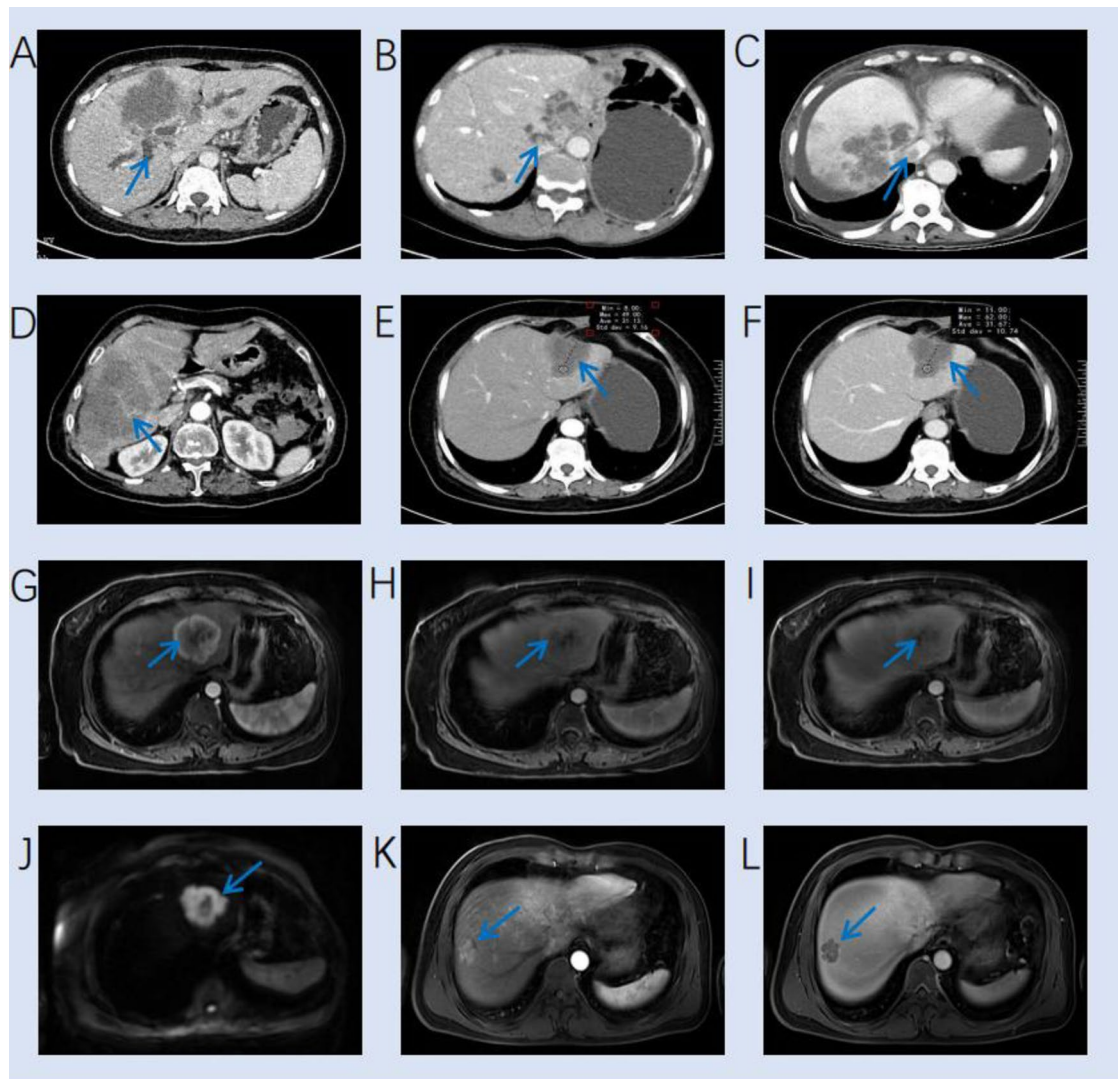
Typical characteristics on MRI and CT images. (A) A venous phase CT image shows a hypodense mass and intrahepatic cholangiectasis (arrow) in the liver. (B) A venous phase CT image shows a hypodense mass in left lobe and intrahepatic duct stone (arrow). (C) A venous phase CT image shows multiple lesions and hepatic vein invasion (arrow). (D) A venous phase CT image shows a hypodense mass with intratumor vessel (arrow). (E–F) An iCCA patient shows stable enhancement on arterial and venous CT images. (G–I) An iCCA patient shows rim-like arterial phase hyperenhancement on arterial phase image, with progressive enhancement on arterial, venous and delayed MRI images. (J) A HCC patient shows target appearance on the high-b-value ($b = 800$) DWI image. (K–L) A HCC patient shows wash-in and wash-out on arterial and venous MRI images, with a pseudocapsule on venous phase MRI image.
